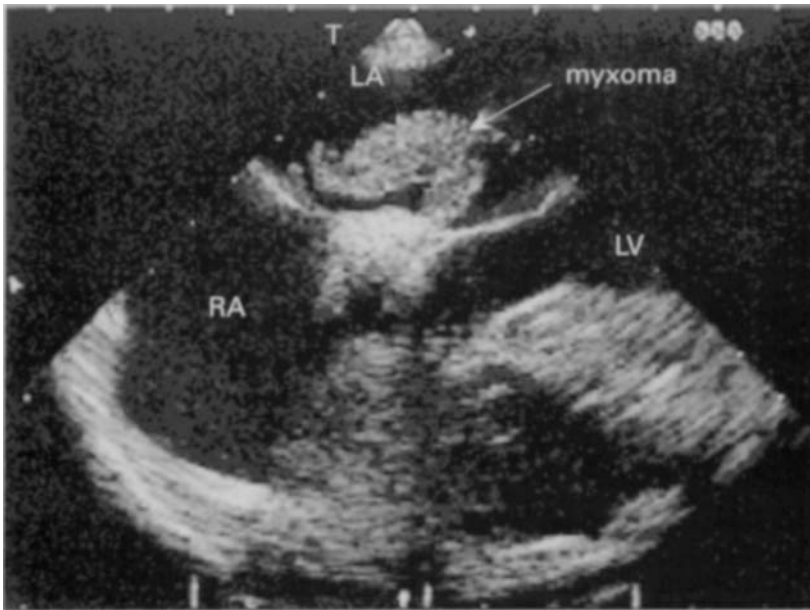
Transoesophageal echocardiogram showing left atrial myxoma. RA = right atrium, LA = left atrium, LV = left ventricle.
